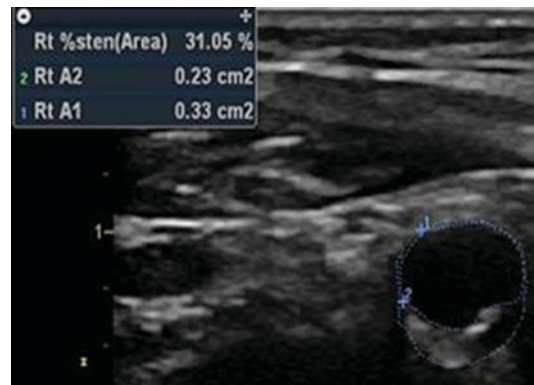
Carotid ultrasound image showing atherosclerotic plaque in a patient without CVRF underwent neck radiotherapy
